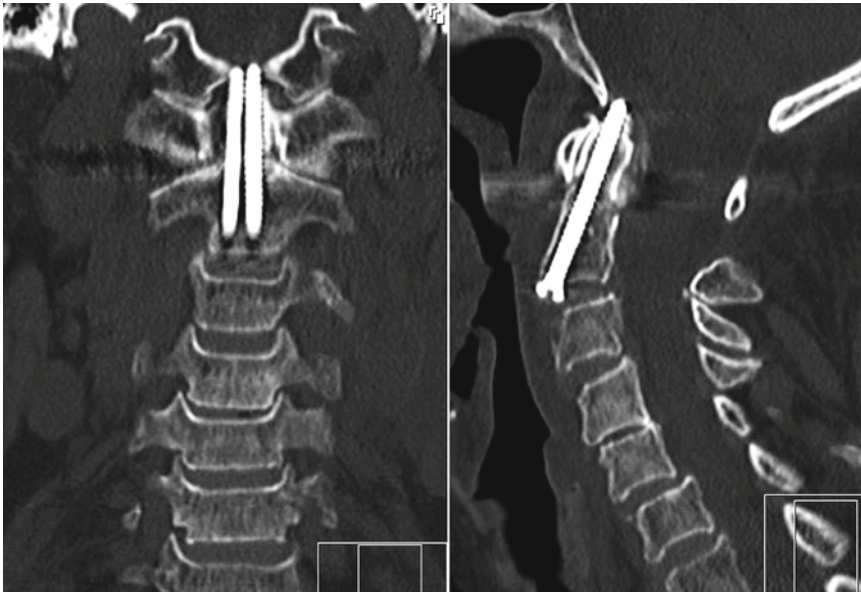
Postoperative coronal (*left*) and sagittal (*right*) CT imaging showing the final positioning of both screws with good distal cortical purchase, although ideal screw lengths would have been about 4 mm shorter (see text)
